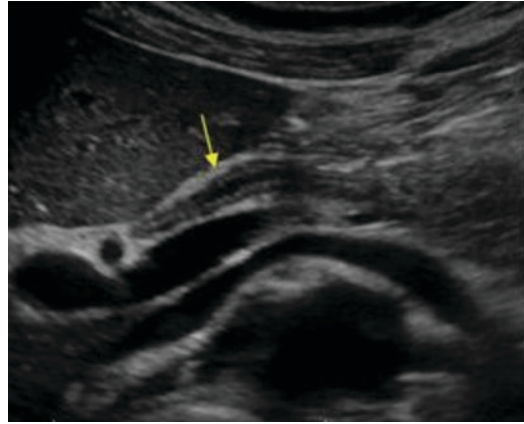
Thickened common bile duct wall found on ultrasonography in a patient with acute cholangitis. No intraductal stones are visualized. (Image used courtesy of Dr. T.S.A. Geertsma)
